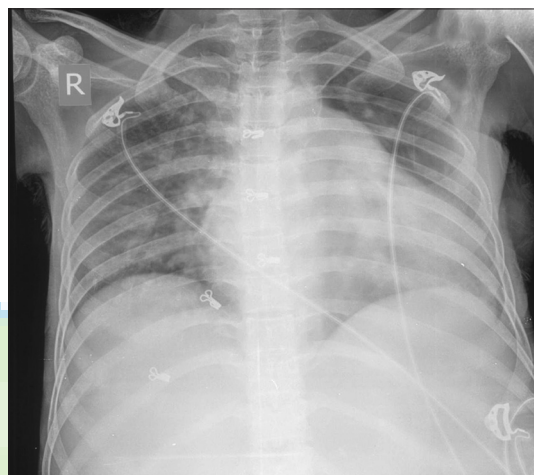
Chest radiograph showing cardiomegaly, right atrial enlargement, dilated pulmonary artery segment, pulmonary plethora, and pulmonary venous hypertension. Combination of these findings is strongly suggestive of ruptured sinus of Valsalva.
